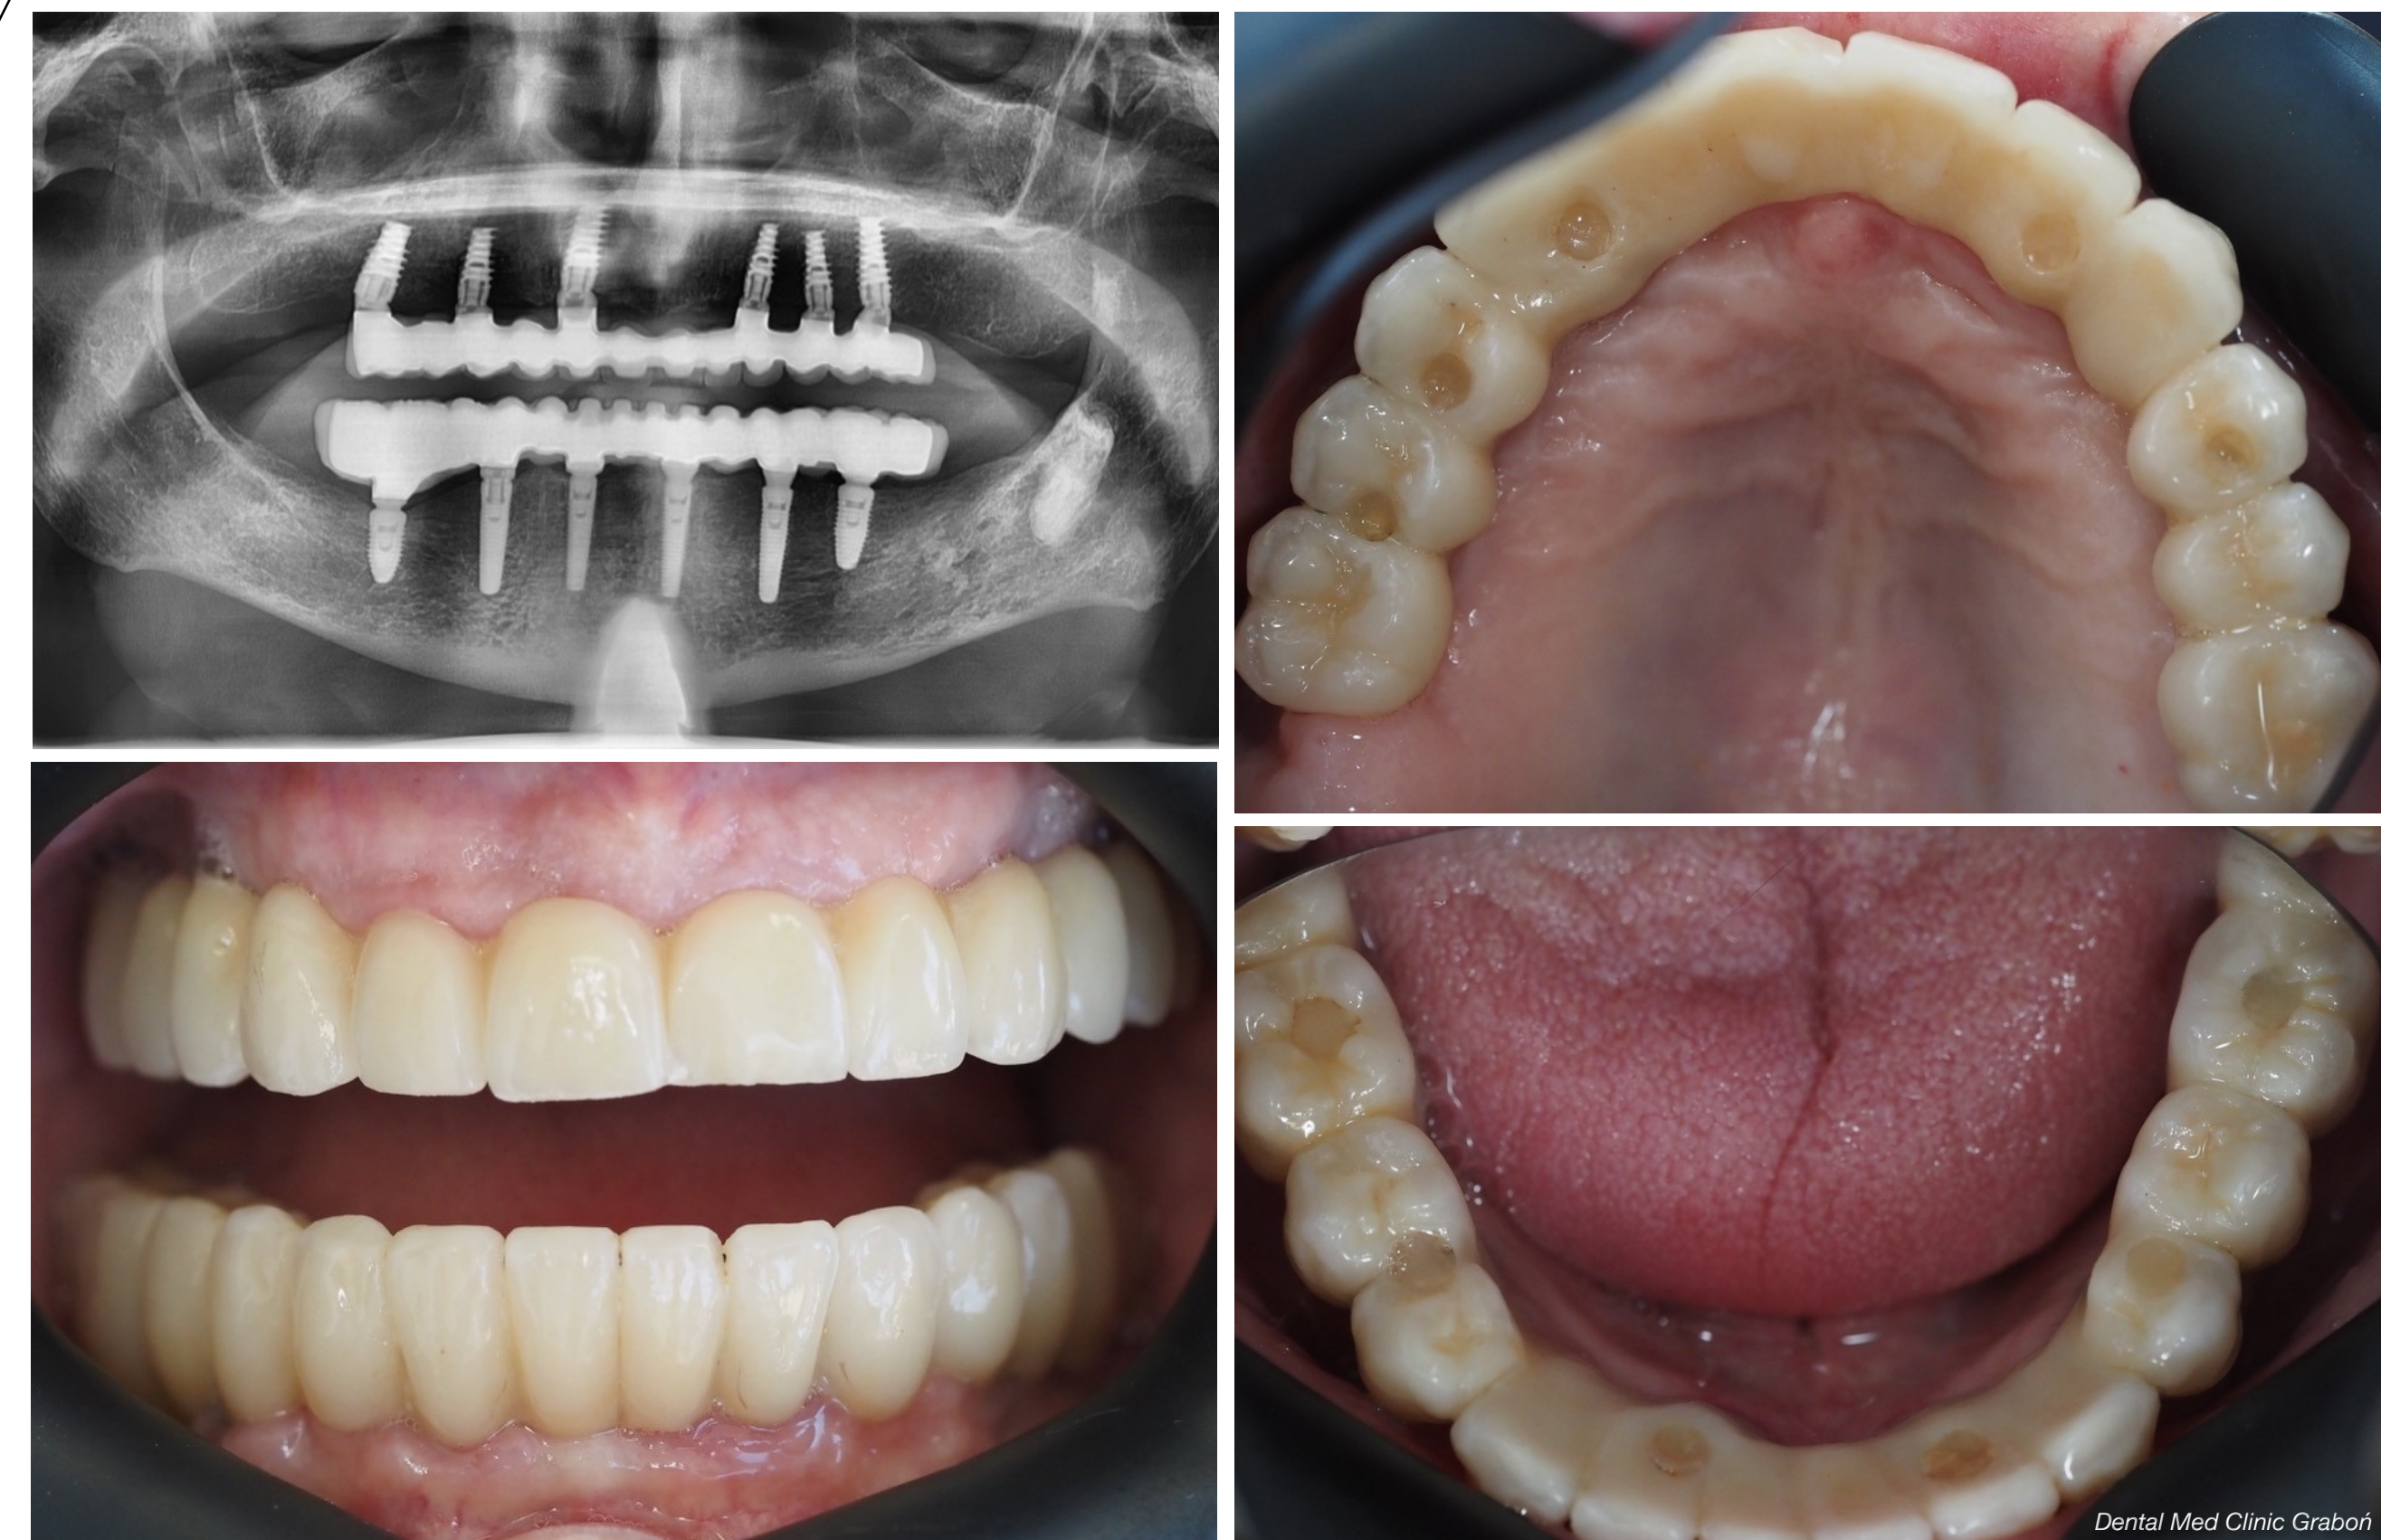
A clinical case of an 89-year-old male patient who presented with terminal dentition with no history of periodontitis or bruxism. He first received 6 NobelActive implants in maxilla inserted at FDI positions 12, 15, 16, 22, 24, and 26. Final prosthesis delivery (FPD) of a 12-unit bridge occurred 4.4 months later. Subsequently, his mandible was treated with 5 NobelReplace CC and 1 NobelActive implants at FDI positions 32, 34, 37, 42, 44, and 47. The FPD of a 14-unit bridge took place 5.5 months later. The radiograph and clinical images were taken at the last follow-up visit (4.3 and 3.6 years after maxilla and mandible bridge placement, respectively).
